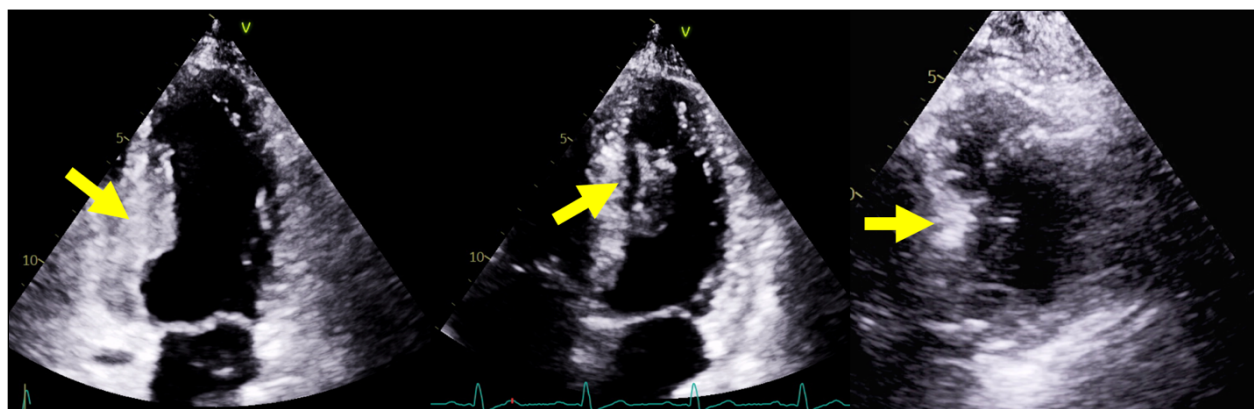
Transthoracic echocardiography (TTE) images. 2- and 4-chamber TTE images with significant thickening (1.4 cm) within the mid inferior and inferoseptal walls (yellow arrows). Short axis imaging on echocardiography was technically limited, however there was no visible mass. Contrast echocardiography was not performed.
